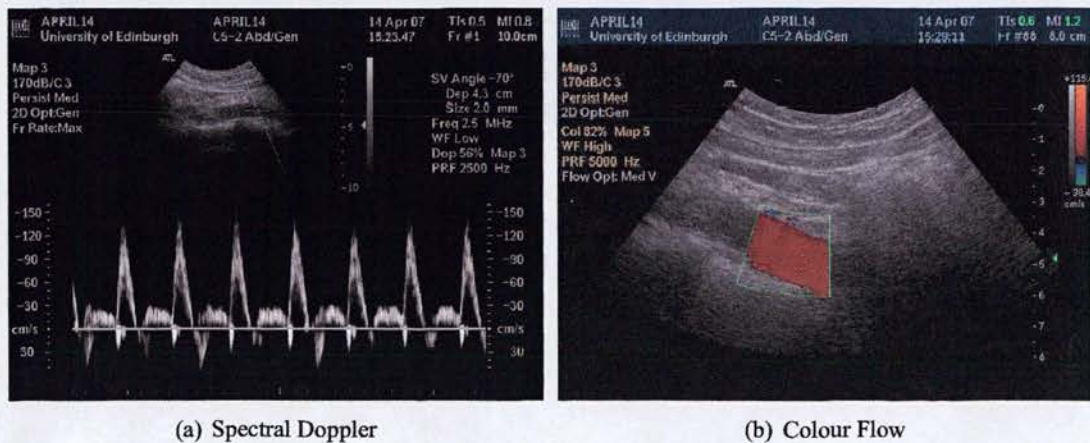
Ultrasonic measurement of blood velocity in the normal aorta.*
